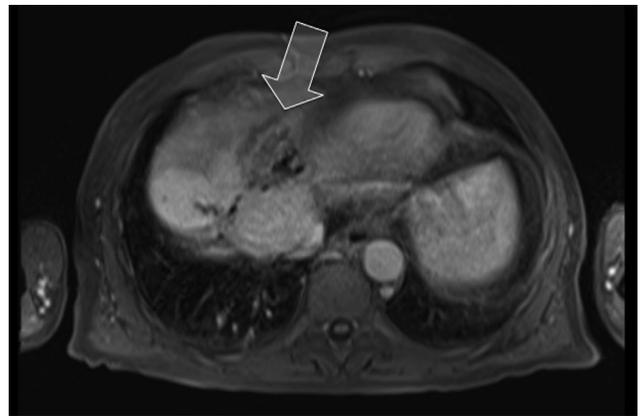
Postinterventional CT scan of patient A obtained before discharge and after ablation of a large colorectal liver metastasis shows complete ablation of the target lesion with hypodense demarcation of the ablation zone and peripheral hyperemia (arrow). The adjacent portal and hepatic veins remain unaffected by IRE.
